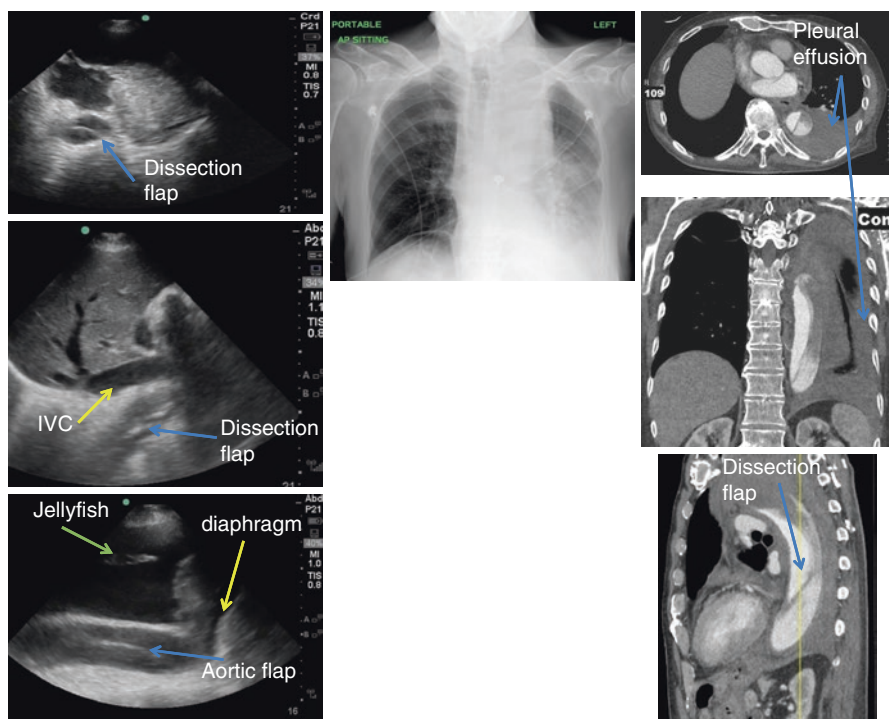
CXR, CT, and ultrasound correlates for Type B dissection. Note the patient has a widened mediastinum and a new left pleural effusion
